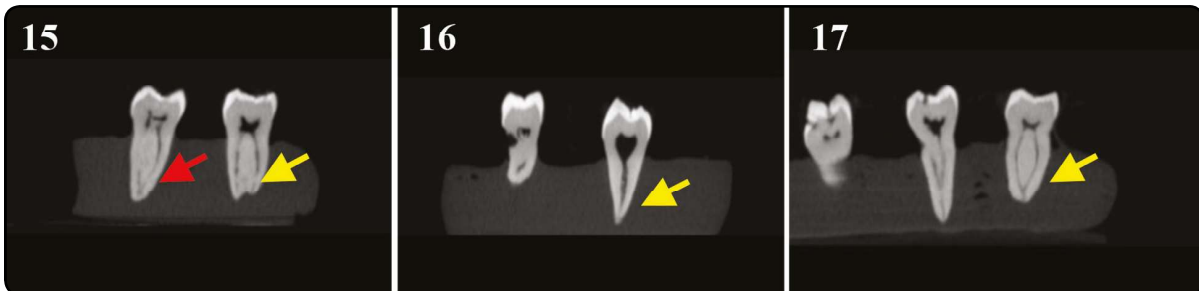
Cone beam computed tomography (CBCT) showing M1 with type IV (yellow arrow) and M1 type II (red arrow) mesial root canal configuration. Fig. 16. CBCT showing M3 with type I (yellow arrow) mesial root canal configuration. Fig. 17. CBCT showing M3 with type II (yellow arrow) mesial root canal configuration.
